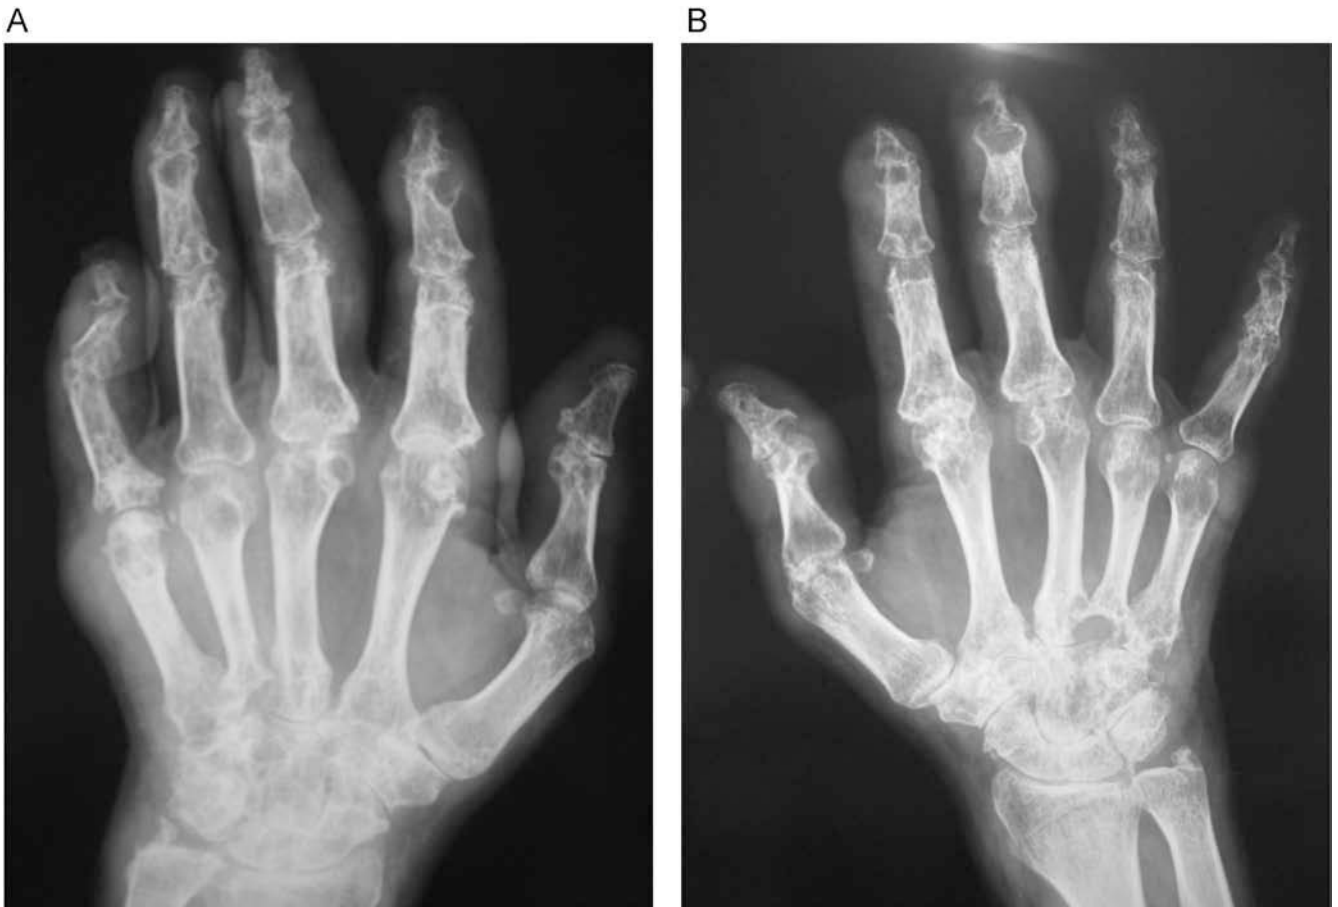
Bone X-ray with increased soft tissues and erosion in the left hand (A) and right hand (B).
